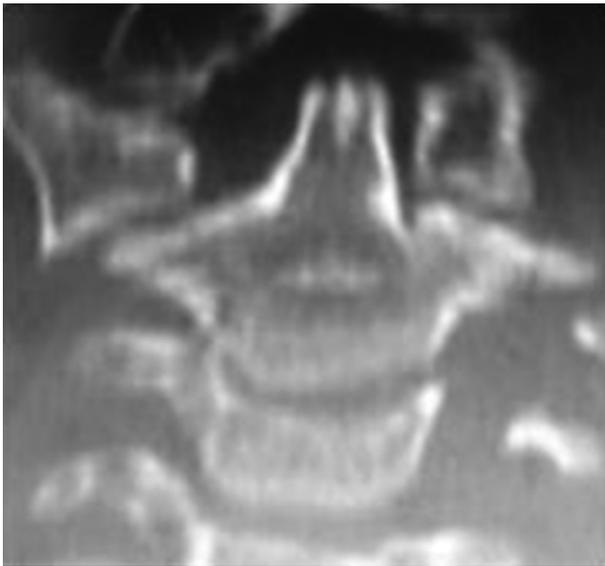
Computed tomography; axial view showing rotational subluxation in C1-C2.
